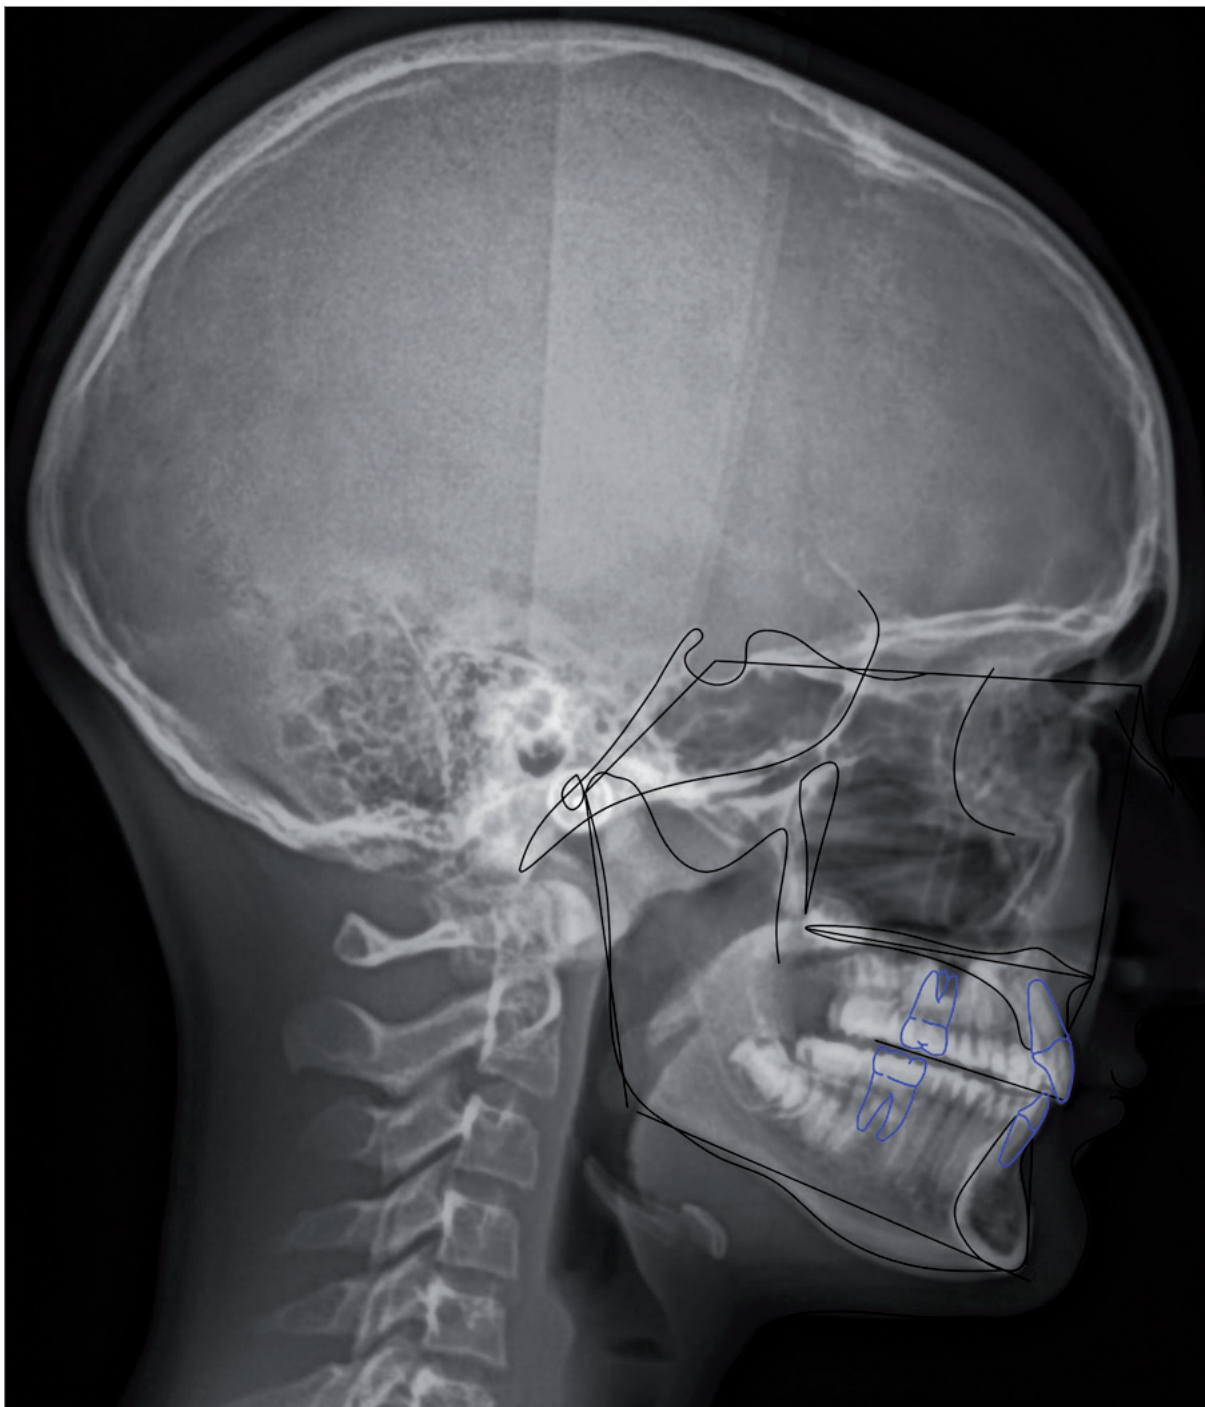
Post-treatment cephalometric radiograph and tracing.
